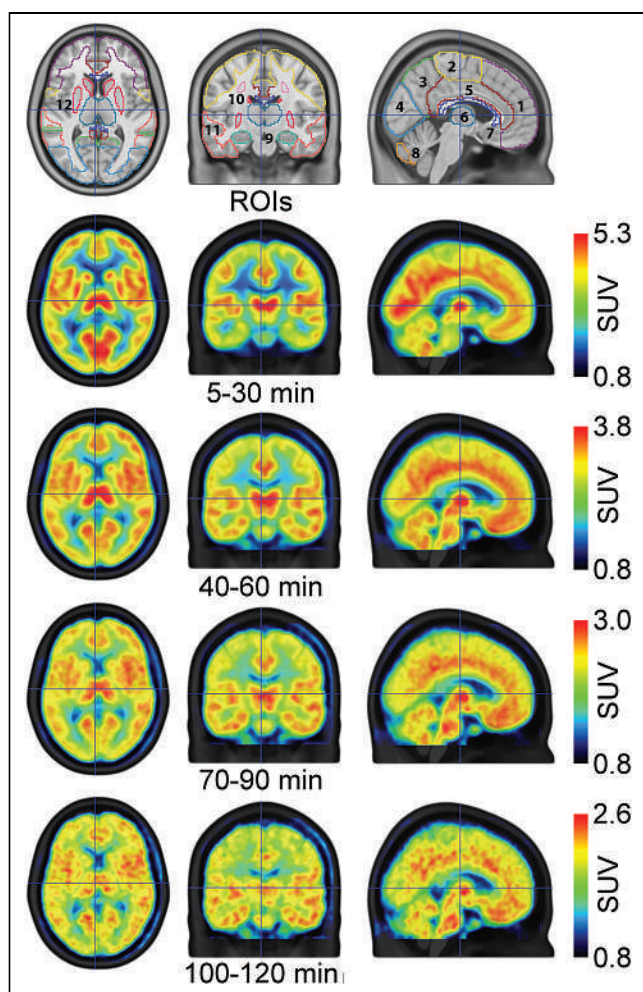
ROIs and SUV_{mean} maps. First row depicts investigated ROIs covering cortical, subcortical, and white matter structures: 1, frontal cortex; 2, somatosensory cortex; 3, parietal cortex; 4, occipital cortex; 5, cingulate cortex; 6, thalamus; 7, corpus callosum; 8, cerebellar gray matter; 9, hippocampus; 10, centrum semiovale; 11, temporal cortex; 12, striatum. Amygdala and cerebellar white matter are not visible in the presented slices (MNI space, $x = -4, y = 16, z = 7$ mm). Remaining rows depict radioligand distribution in terms of SUV for various time points (averaged across subjects).
